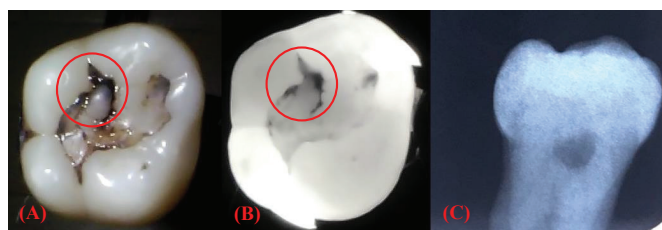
Sample 7 under visible light (A), NIR light (B), and X-ray (C).
